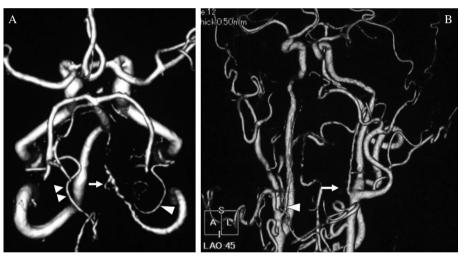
Three-dimensional computed tomographic angiography. (A) The right posterior inferior cerebellar artery (PICA) branched from the dissected portion of the right vertebral artery (arrow). The hemispheric branch of the PICA was perfused by some other artery coming from the jugular foramen (arrowhead). As for the left PICA, it entirely came from the left jugular foramen (double arrowhead) instead of branching from the vertebral artery. (B) In the cervical portion, the right ascending pharyngeal artery (APA) branched from the external carotid artery (arrowhead), and the left APA branched from the inside of the bifurcation (arrow).
